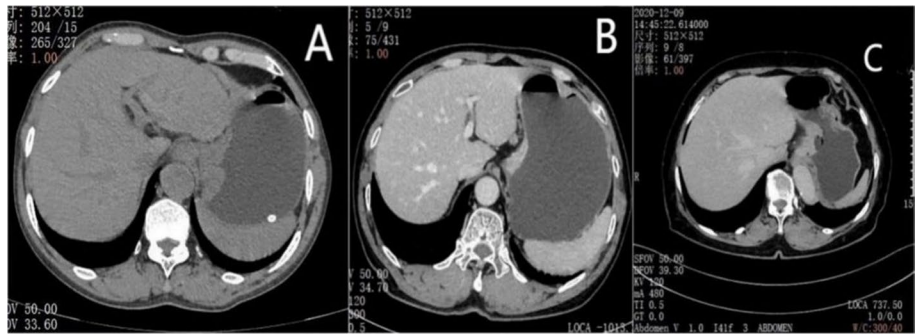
Preoperative CT images of case 1–3. A Preoperative CT image of case 1; B Preoperative CT image of case 2. C Preoperative CT image of case 3
